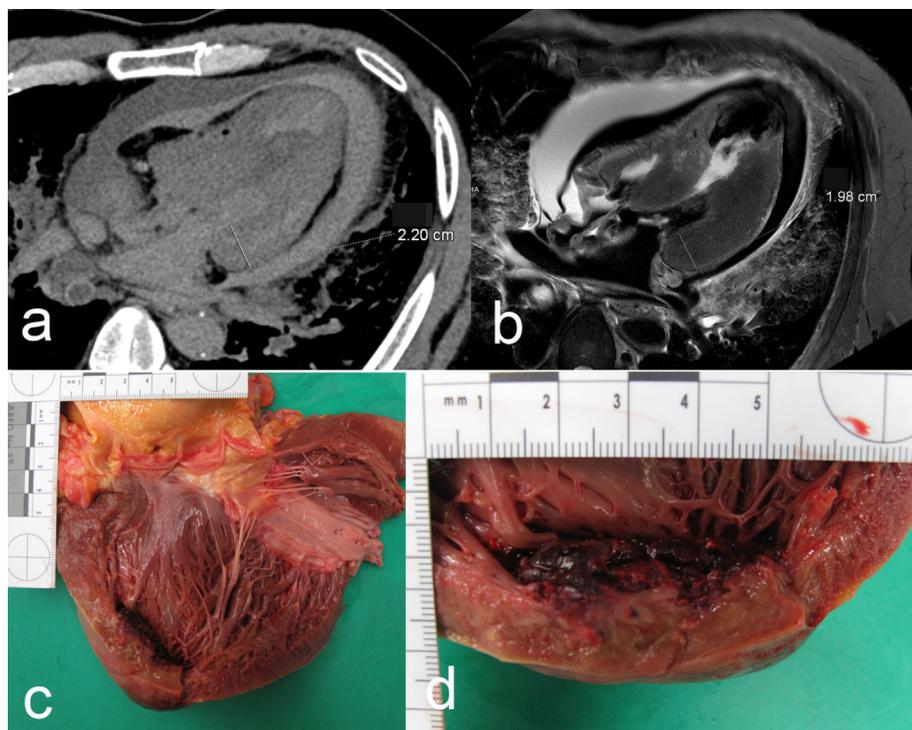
Left ventricular free wall thickness measurements in postmortem imaging of a case with pericardial effusion for comparison between PMCT and PMMR. Four-chamber views of the same heart on PMCT soft tissue kernel (a) and PMMR T2-weighted turbo spin echo sequence (b) for the measurements of the left ventricular wall. Note the presence of hemopericardium with the typical target sign revealed around the heart. Pericardial blood volume was 530 ml and anterior left ventricular wall thickness 13 mm at autopsy. Note also the changes of the wall at the apex of the heart indicative of cardiac wall rupture, which was confirmed during autopsy (c, d).
